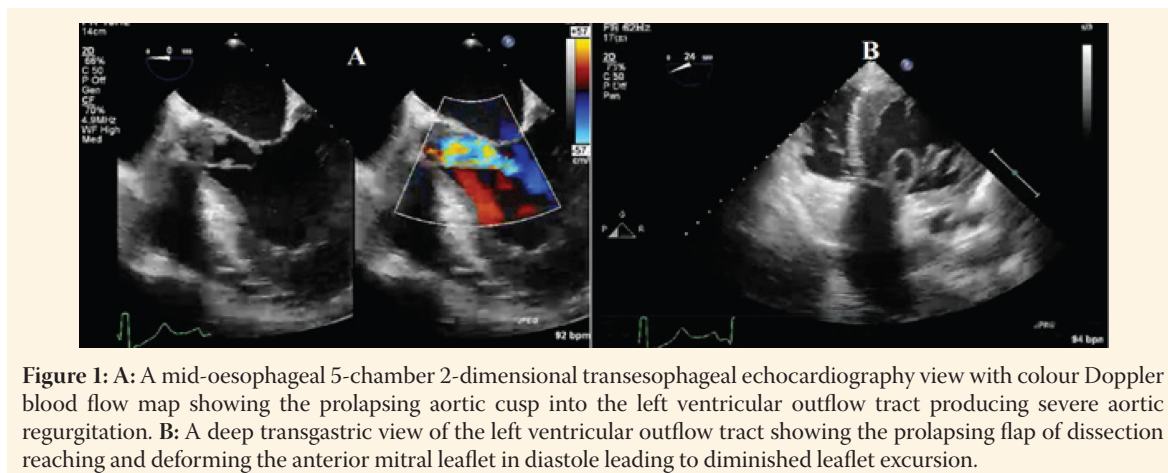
A: A mid-oesophageal 5-chamber 2-dimensional transesophageal echocardiography view with colour Doppler blood flow map showing the prolapsing aortic cusp into the left ventricular outflow tract producing severe aortic regurgitation. B: A deep transgastric view of the left ventricular outflow tract showing the prolapsing flap of dissection reaching and deforming the anterior mitral leaflet in diastole leading to diminished leaflet excursion.
